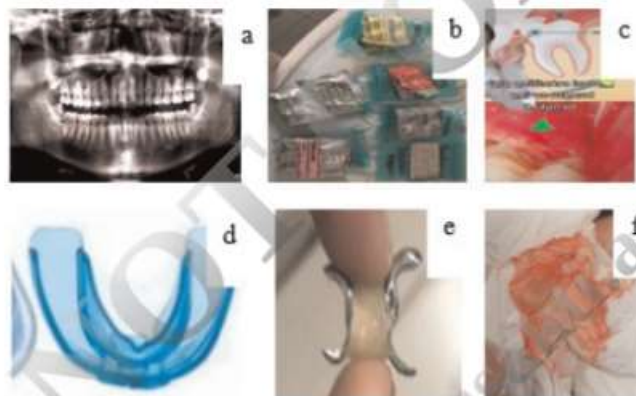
Other image; a. radiograph, b. medicine, c. ecommerce, d. dental material, e. dental education f. miscellaneous.
